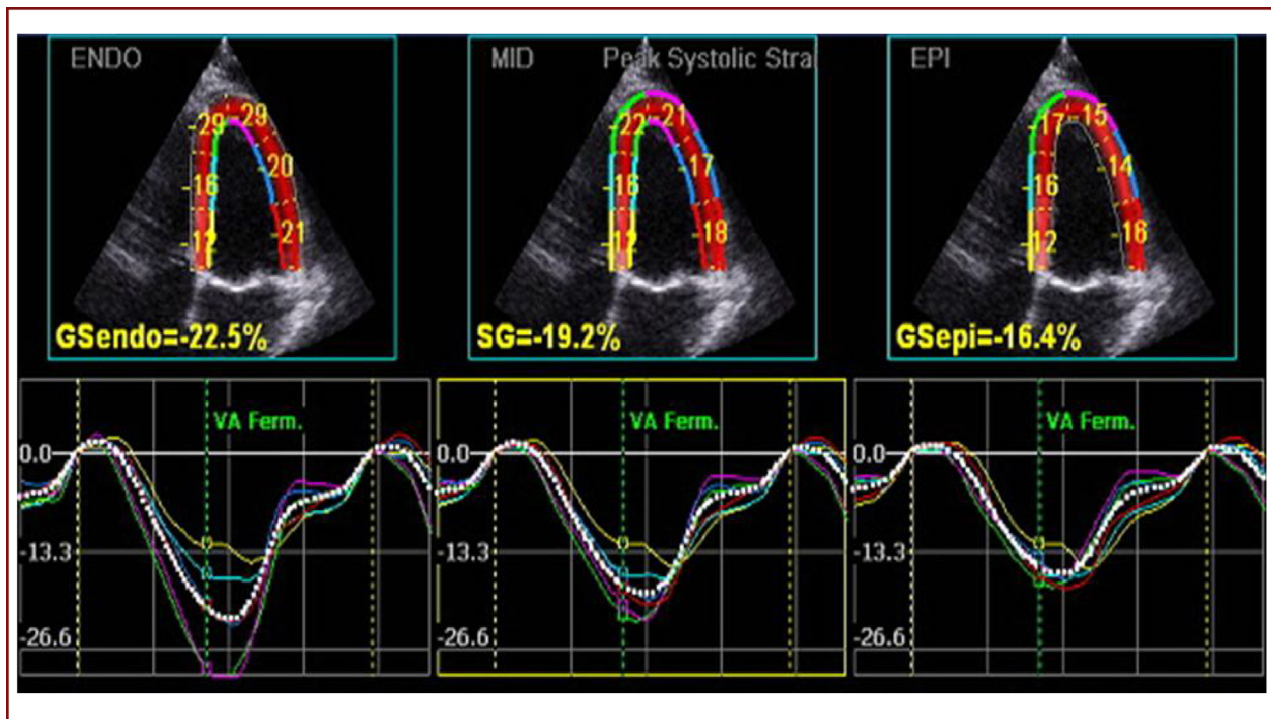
Global strain of endocardial, mid-myocardial and epicardial layers in apical four-chamber view using EchoPAC software.
